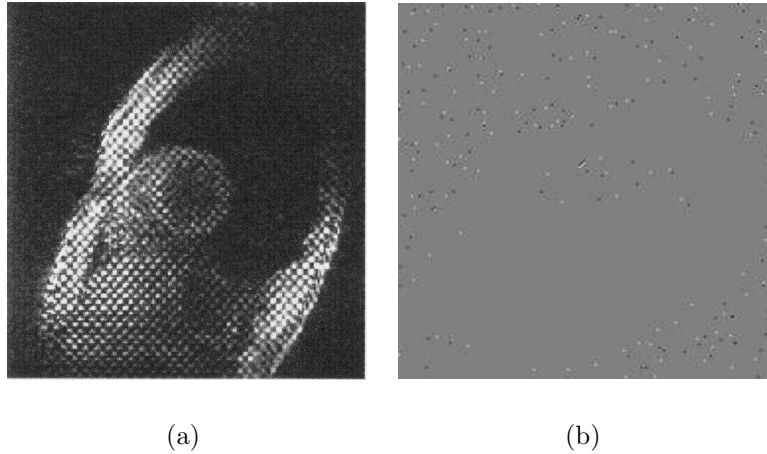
(a) The original MRI image; (b) The residues are marked black and white for negative and positive residues respectively. The number of residues is clearly larger in the outer areas where there is air and areas of the image with large motion compared to the areas with tissues as seen in the original MRI image.
